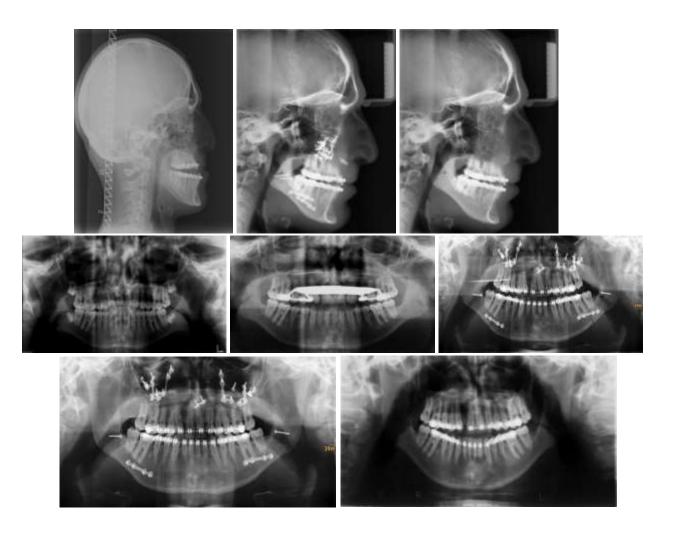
X-ray images of the patient before, after and in the dynamics of observation 24 months after bimaxillary surgery. Panoramic photographs of the patient before surgery, after intensive expansion of the upper jaw, after bimaxillary surgery and 12 and 24 months after surgery.
